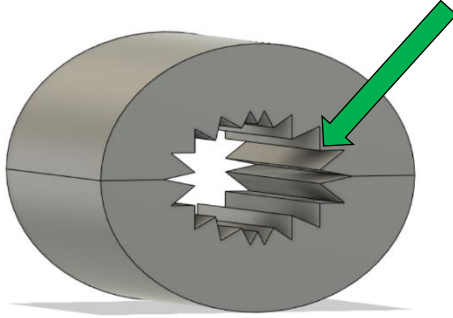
One-Piece Sheath Design. Computer-aided design (CAD) rendering of the one-piece sheath design. The device exhibits shape of an oblong (oval) shape with an opening, or hole, in the center (green arrow) for the handle of an intracardiac ultrasound catheter to be inserted. The inner surface of the hole is lined with flexible ridges to allow the sheath to expand, if needed, to fit catheters of varying sizes and shapes.¹⁶
